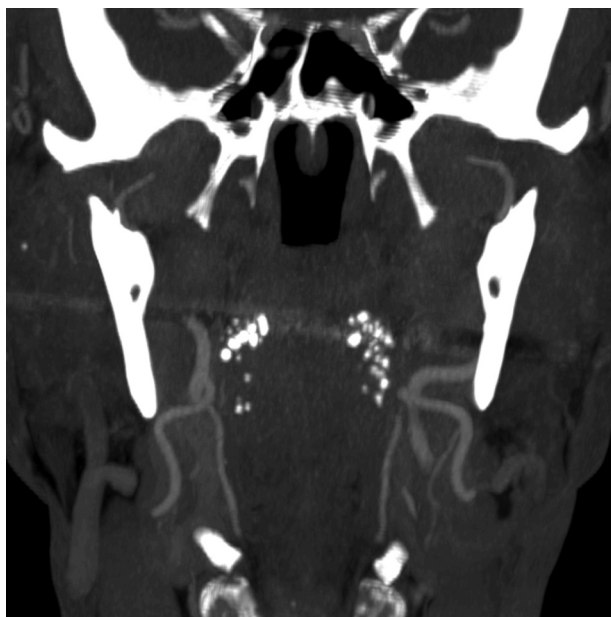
Cervical CT examination in the coronal plane after IV administration of iodinated contrast material using maximum intensity projection (MIP) reconstruction.
